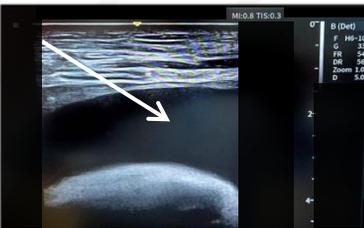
The white arrow indicates the needle entry trajectory during pericardiocentesis via parasternal approach.
